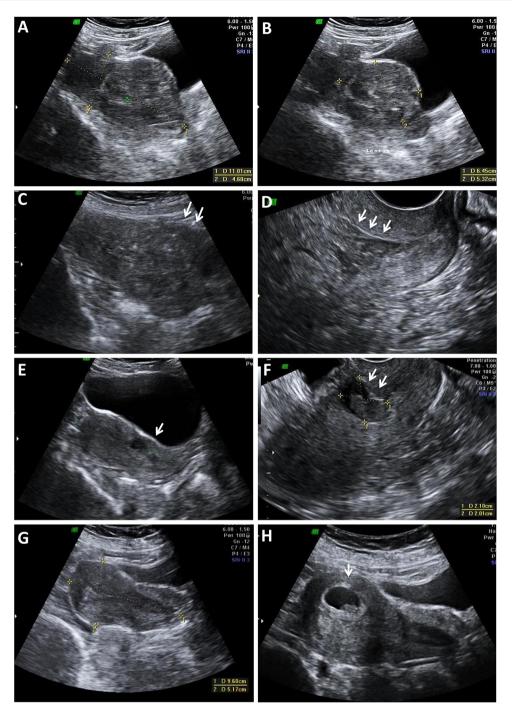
A typical ultrasound findings in CSP after attempted D&C. a, b Transabdominal USG revealed echogenic lesion in the lower segment of the uterus. c Outer contour of the uterus in the lower segment appeared hazy and irregular with loss of endomyometrial interface. d Transvaginal scan depicting isoechoic lesion distending
